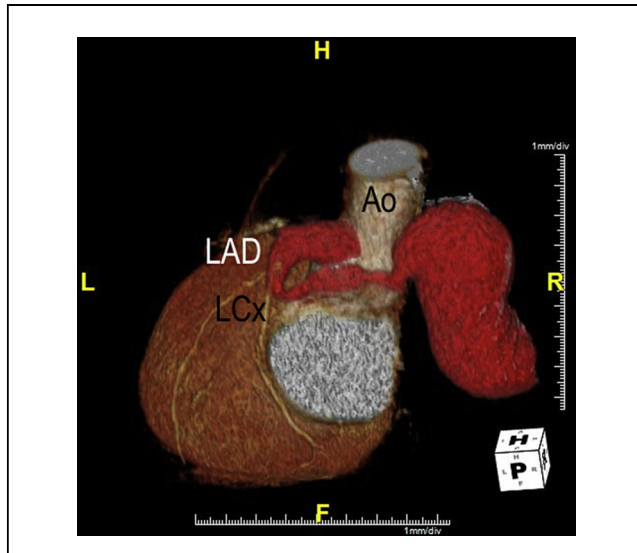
CTA With 3D Reconstruction
